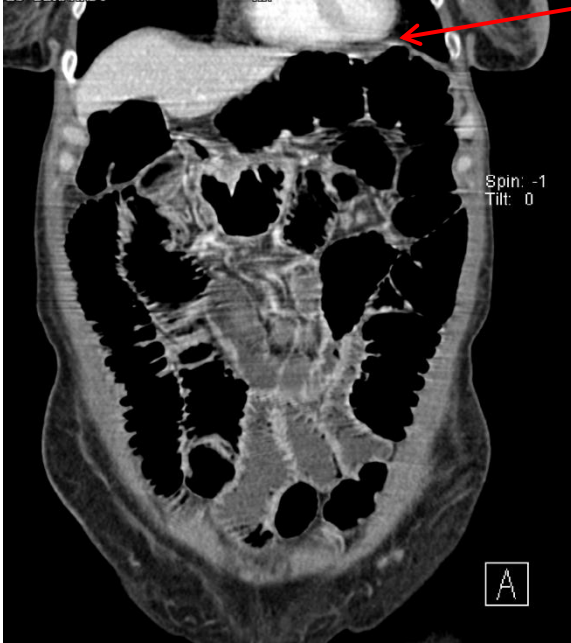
Abdominal CT before scan IVIG therapy.
